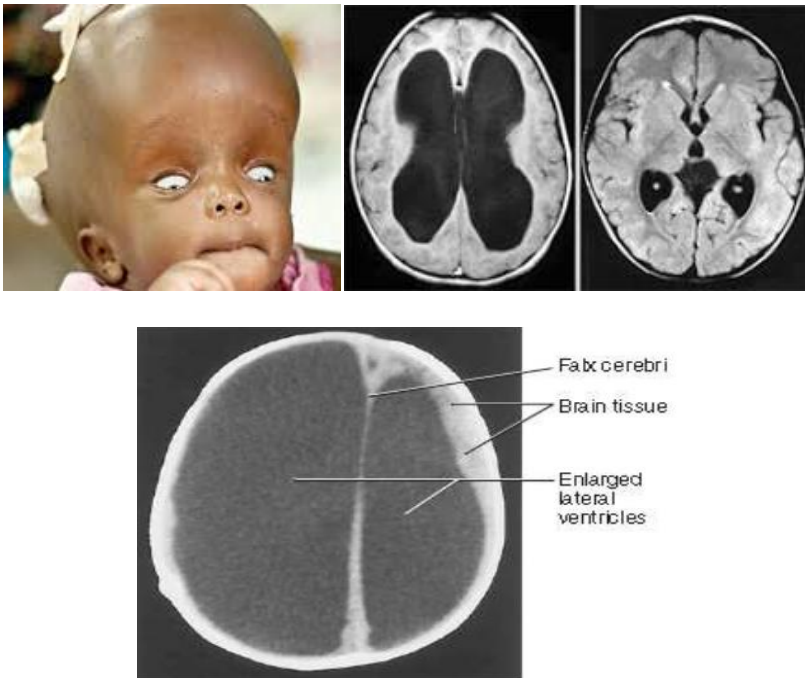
Congenital hydrocephalus showing the findings on Brain MRI and CT scan
